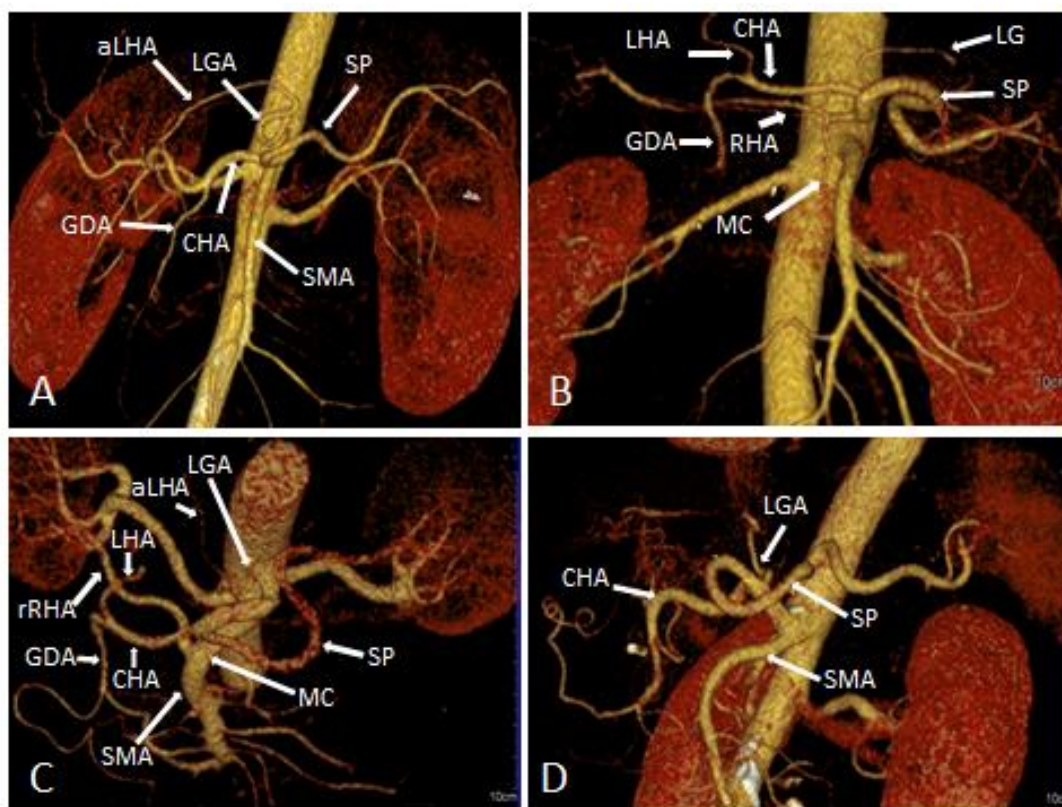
3D VR images (A) Bifurcation of the CT shows the hepato-splenic trunk (Uflacker's type II), LGA arises directly from the aorta. (B) CT has four branches CHA, LGA, SP and RHA which originates directly from CT as a fourth branch and then MC originates from RHA. (C) CT shows coexistence of Hepato-splenic and Celiac-colic trunks (Uflacker's type II + VII), LGA originates directly from the aorta and gives off an accessory LHA, notice the replaced RHA arises from the SMA. (D) Celiac-mesenteric trunk (Uflacker's type VI) where the celiac trunk and SMA have a common point of origin.
